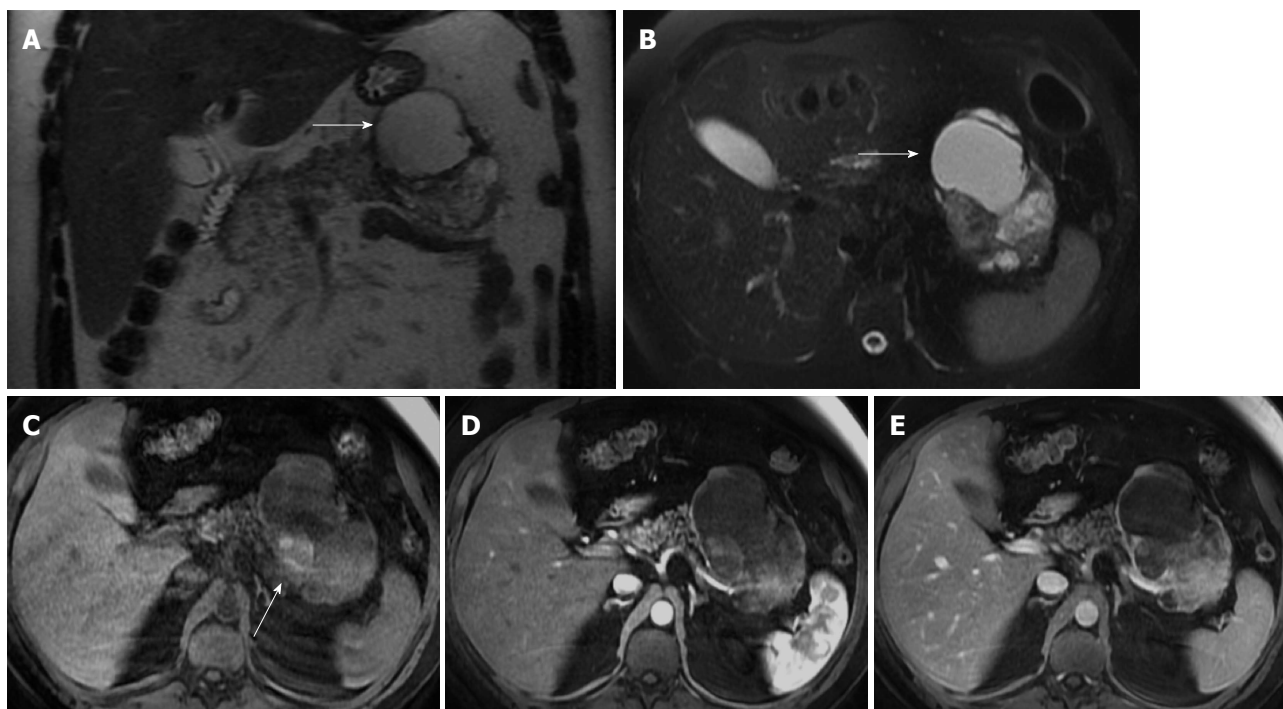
Solid pseudopapillary tumor. Coronal (A) and axial fat-suppressed (B) T2-weighted SS-ETSE, pre-contrast fat-suppressed T1-weighted (C) GRE and post-gadolinium fat-suppressed T1-weighted GRE images acquired in the arterial (D) and venous (E) phases of enhancement. A large well-demarcated and encapsulated mass is located in the tail and body of the pancreas. The mass shows heterogeneous signal intensity, with cystic (arrows, A and B) and hemorrhagic areas (arrow, C). The solid component of the lesion shows progressive enhancement over time. A mass with these characteristics, appearing in a young patient is most likely related with solid pseudopapillary tumor. SS-ETSE: Single-shot echo train spin echo; GRE: Gradient echo.
